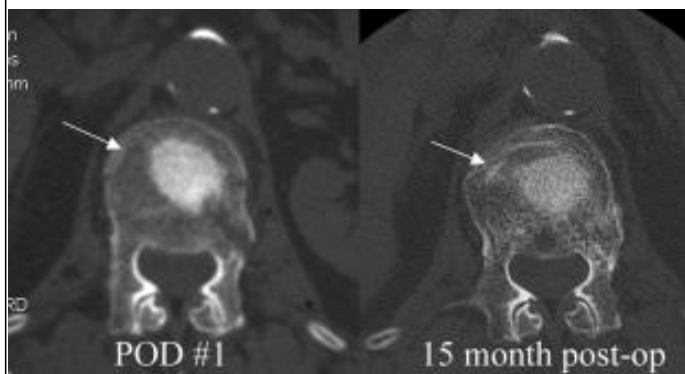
Fracture in a 79 y.o. female on chronic steroids for pulmonary fibrosis. DEXA T-score of -1.4. Comparable CT axial views from POD #1 and 15 mo post-op show evidence of bone graft incorporation circumferentially around the mesh. The access tunnel appears to be filled in with new bone. White arrow depicts original fracture line, which appears healed on the 15 mo CT.
